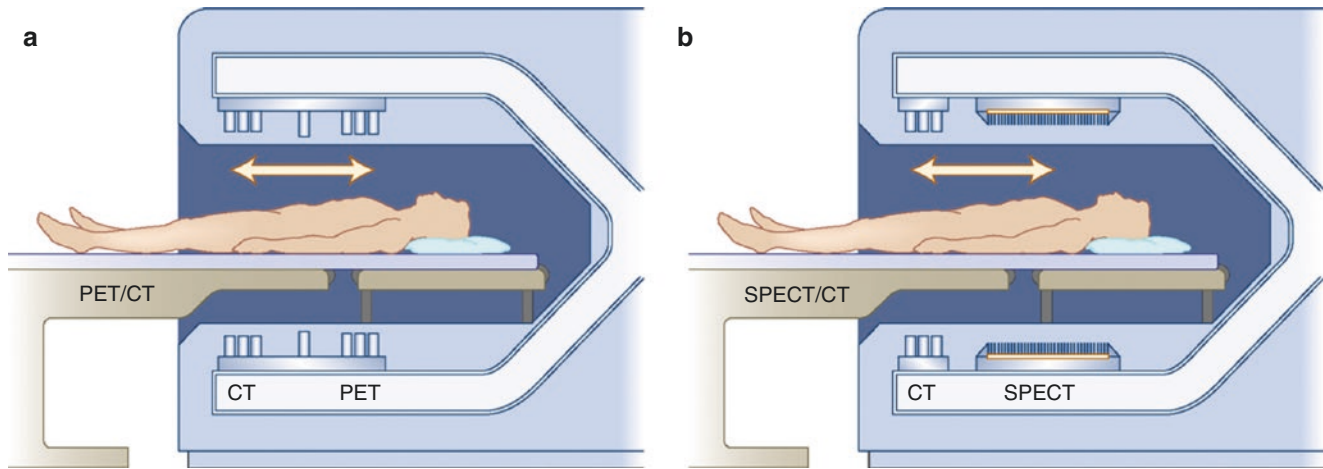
Hybrid PET/CT and SPECT/CT imaging systems. Hybrid systems, which physically couple a CT scanner with a PET (a) or a SPECT (b) scanner, are now in routine clinical use. The coupled CT scanner, ranging from 1 to 64 slices, is commonly used for attenuation correction and, if supported by the CT scanner, can be used to evaluate
